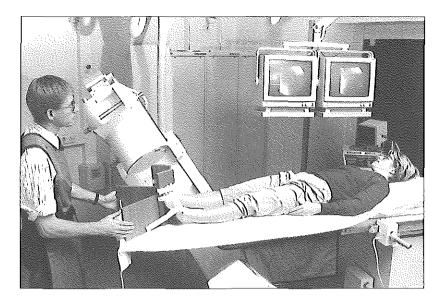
Photograph shows the technique used in the present study. Stress was applied with a hinge device. An apparatus with an image intensifier was used. Radiographs were taken with the x-ray beam centered on the subtalar joint with an angle of 30° latero-medially and 40° caudo-cranially.
